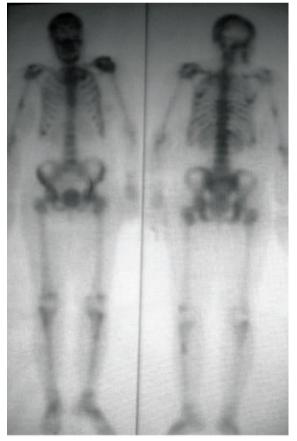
Whole-body bone scintigraphy showing increased uptake in the skull, ribs, left shoulder, thoracic and lumbar vertebral bodies, right humerus and left tibia.
